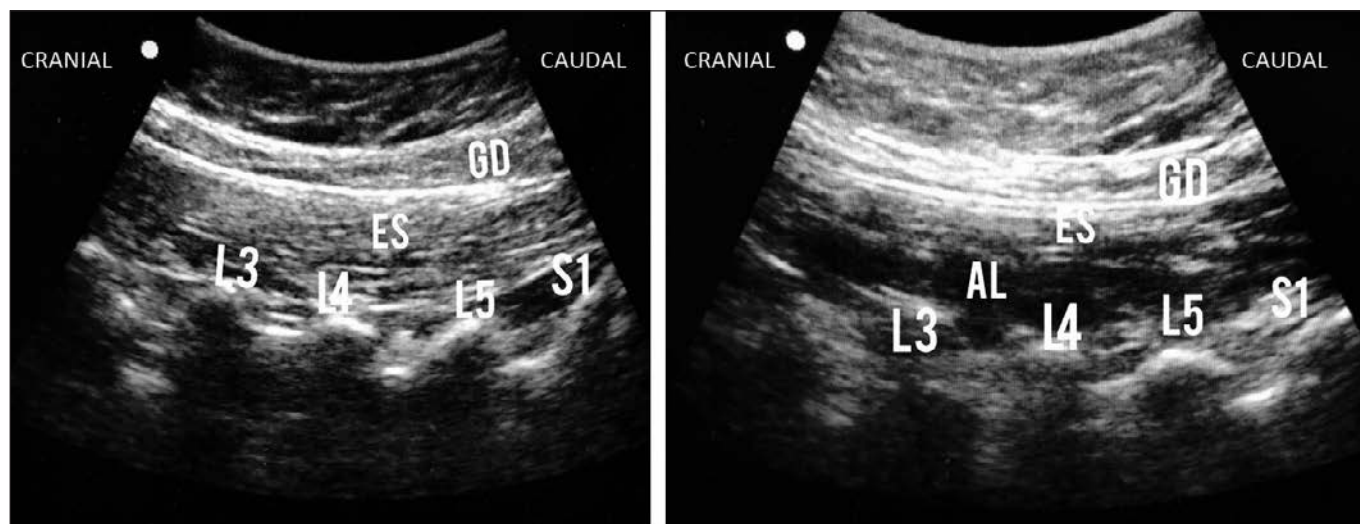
Lumbar ultrasound anatomy
